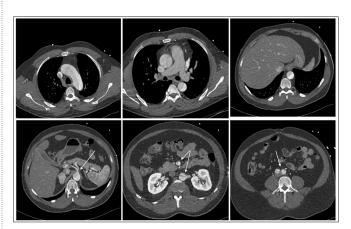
Unenhanced CT Aorta. Compared to the previous views there is higher attenuation on the false lumen. The first three top images portray the dissection on three different levels inside the thorax. The bottom left image shows the coeliac trunk arising from the true lumen of the abdominal aorta. The middle bottom depicts the single SMA dissection and the left renal artery arising from the false lumen, while the bottom right image shows the extension of the dissection beyond the iliac bifurcation, ultimately reaching the common femoral arteries. CT, Computed tomography; SMA, superior mesenteric artery.
